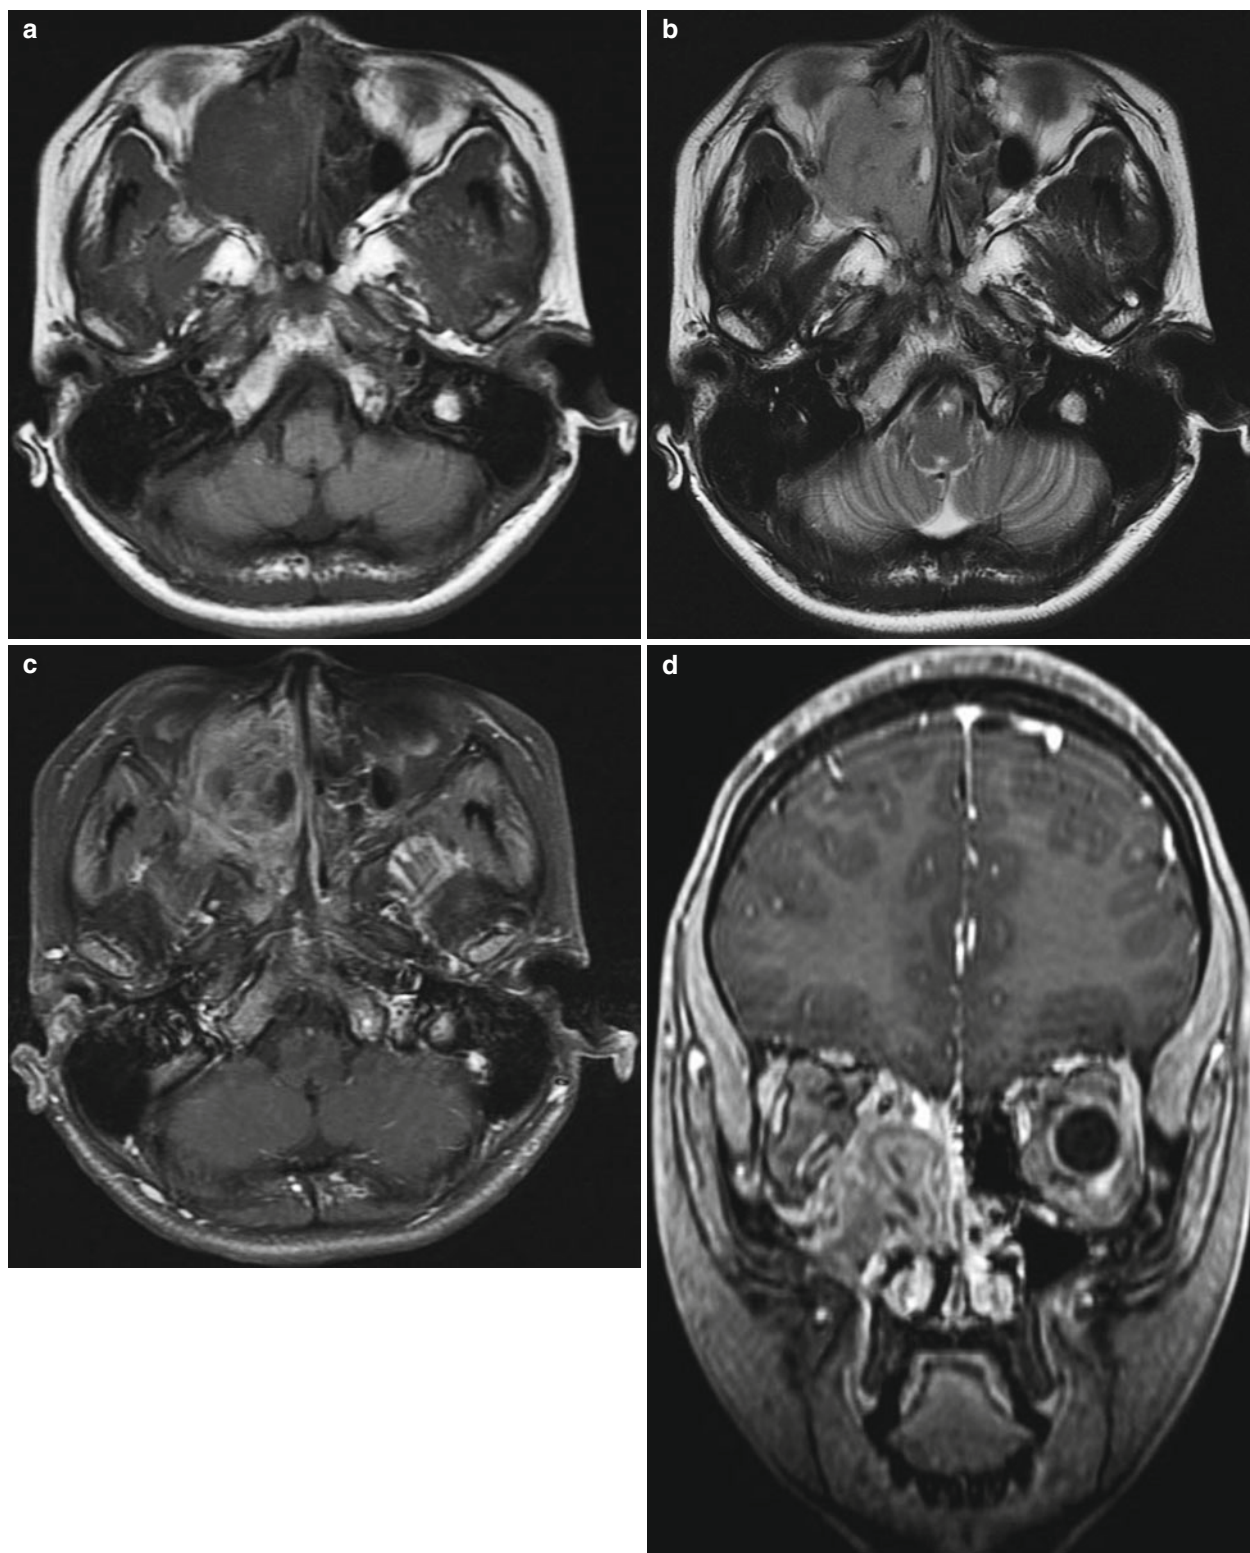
Rhabdomyosarcoma in a 15-year-old girl. (a) Axial T1-weighted MR image shows a bulky soft tissue mass of iso-signal intensity relative to muscle in the superonasal aspect of the right orbit. (b) Axial T2-weighted MR image shows a heterogeneous slightly high signal intensity of the mass with internal necrosis and fluid-hemorrhage
